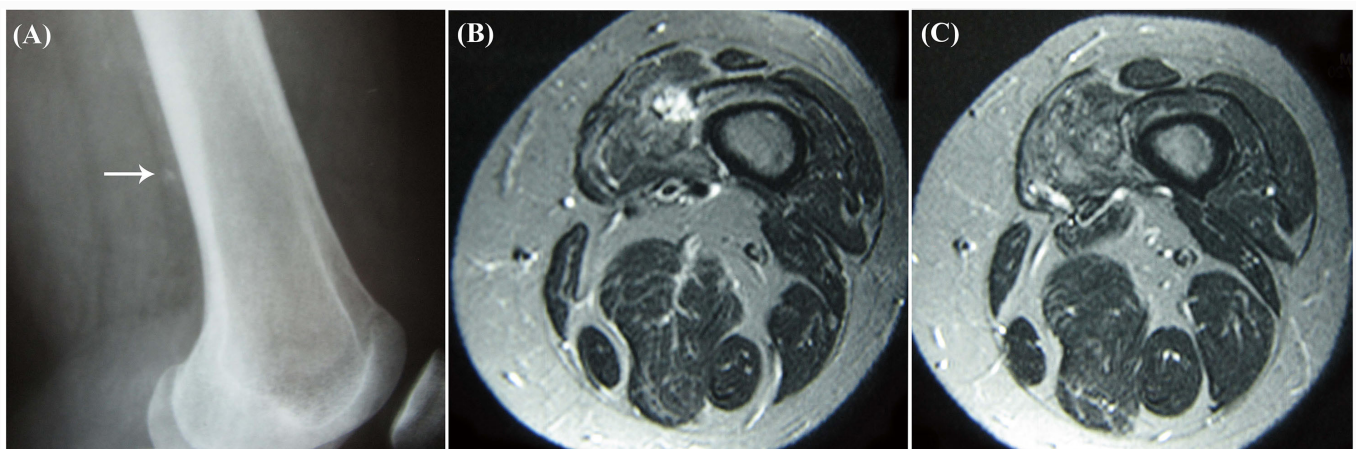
(A) Radiograph of a cavernous hemangioma of vastus medialis showing an ill-defined calcification; (B) T2-weighted MRI showing an infiltrative mass of high-intensity lobulated signal; (C) T1-weighted MRI showing an infiltrative mass of intermediate signal intensity within the muscles.
